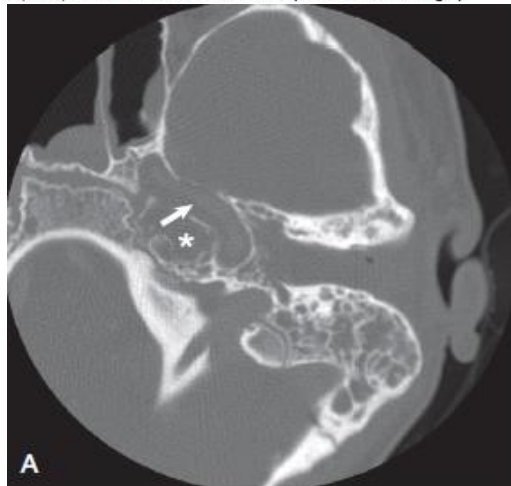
Computed tomography (CT) and magnetic resonance imaging (MRI) are helpful adjuncts in the diagnosis of petrous apicitis. A, In the CT scan, the fluid-filled petrous apex (arrow) can be compared with the opposite air-filled apex. B, In the MRI scan, the area of increased signal is present in involved apex (arrow). An amber-colored, fluid-filled cyst was found at surgery.
